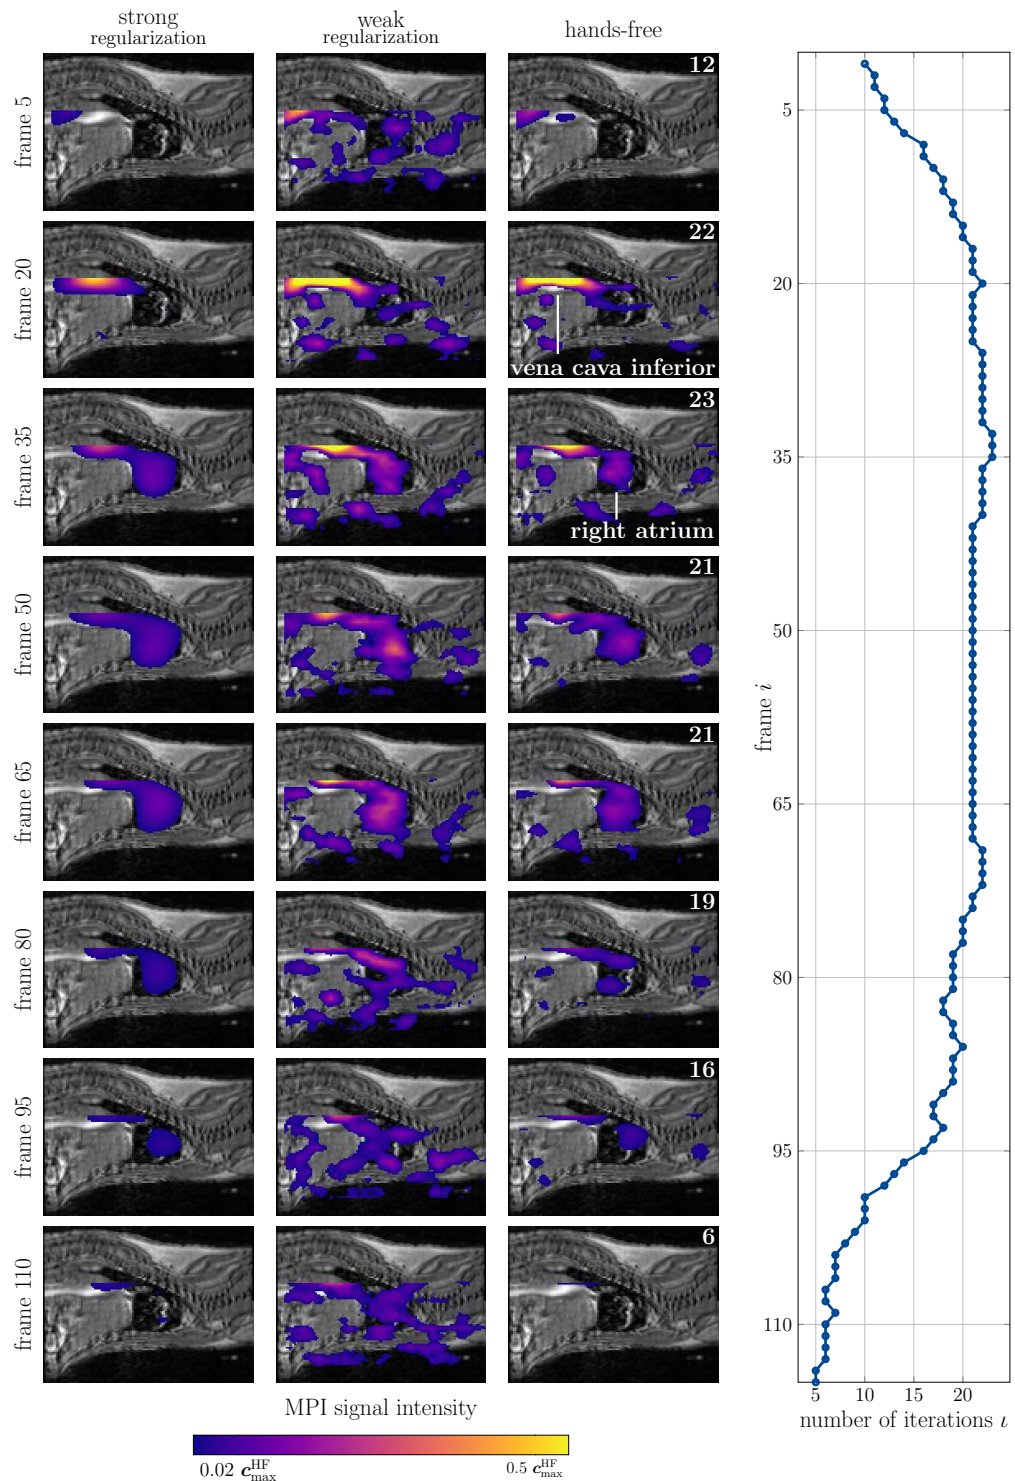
MPI results of the in vivo bolus visualized on top of corresponding MRI data. Shown is a solution using strong respectively weak regularization as well as the hands-free method on several frames with equidistant time difference. The number of iterations after which the stopping criterion was triggered is superposed in white. The results are normalized to the maximum of the hands-free solution c_{\max}^{HF} , with the common colorbar given below. Furthermore, the number of iterations of the hands-free method over the course of the frames is given on the right side.
